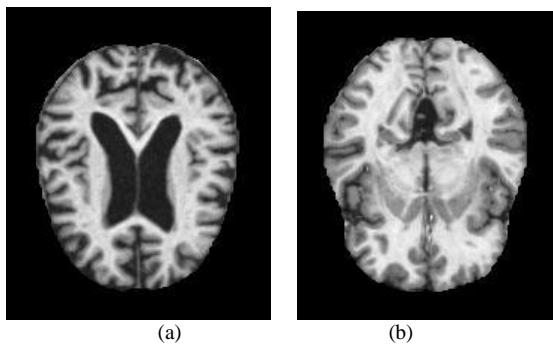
Shows (a) AD MRI brain scan image (b) Normal MRI brain Scan image.
